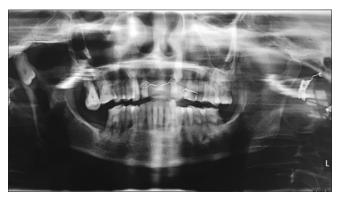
Orthopantomogram shows ectopic third molar in the right condylar region in an inverted position with a radiolucent image around the third molar crown and generalised bone loss
